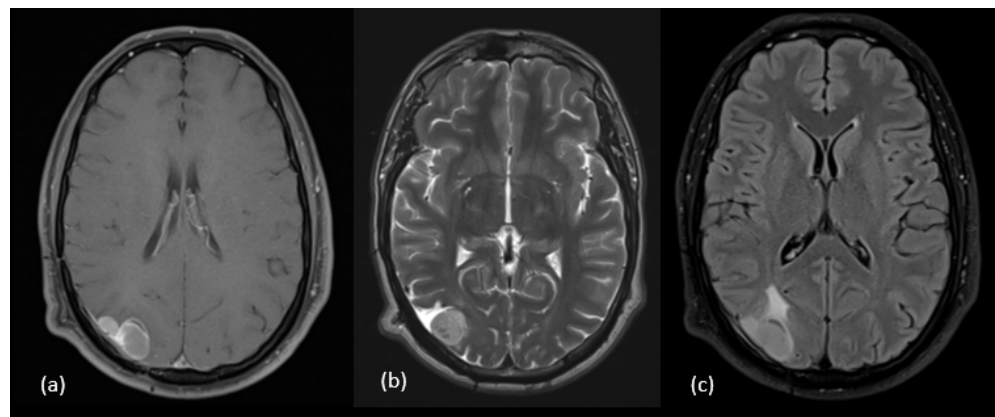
Postcontrast T1-weighted axial (a), T2-weighted axial (b) axial flair (c) revealed tumour recurrence.
